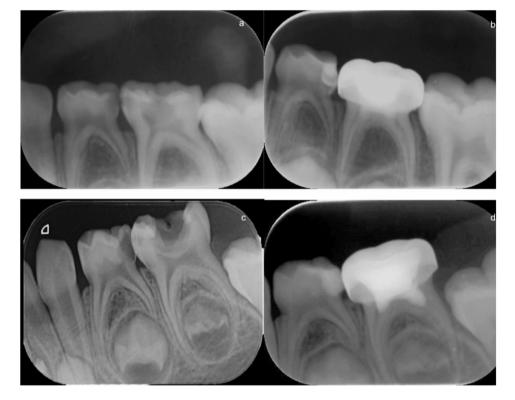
Periapical radiographs of primary second molars before (a, c) and 18 months after (b, d) pulpotomy treatments. (b: pulpotomy with Biodentine, d: pulpotomy with MTA)
